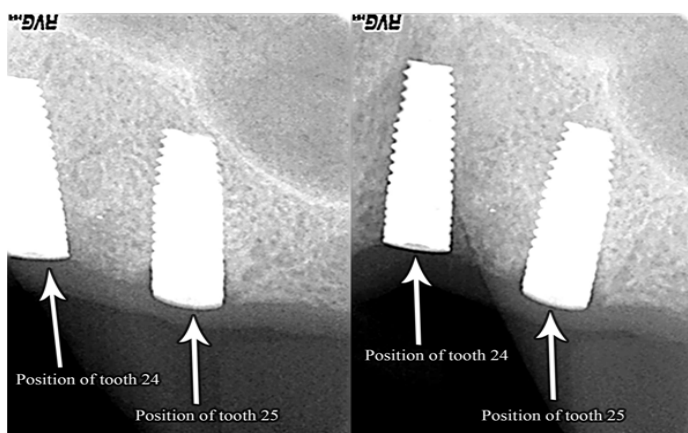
X-rays of dental implants in the positions of teeth 24 and 25 (upper left first and second premolar). The
